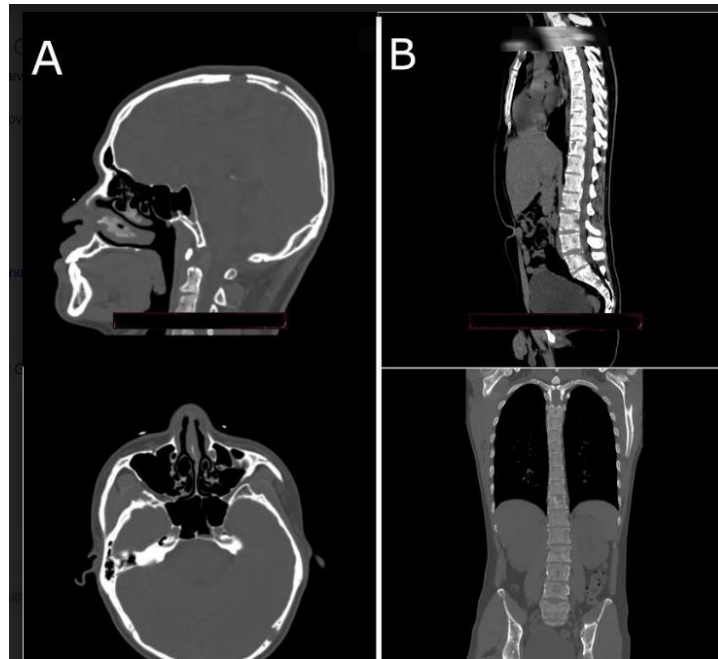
Cerebral and thoraco-abdomino-pelvic CT scans without injection.
